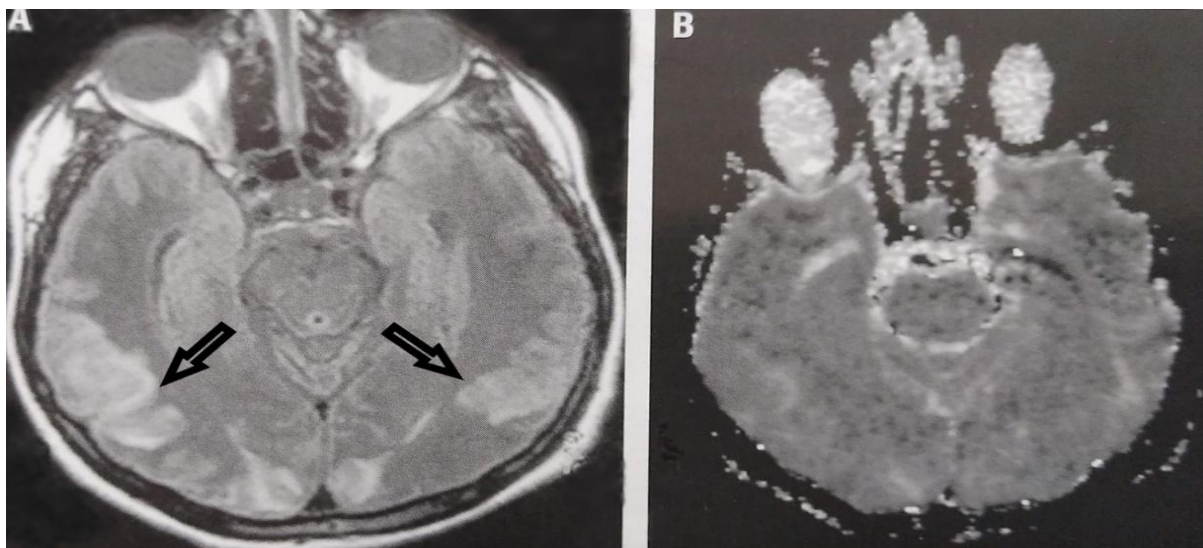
A. Fluid-attenuated inversion application recovery (FLAIR) sections. Symmetrical hyperintense vasogenic edema findings in bilateral occipitotemporal regions. B. Apparent diffusion coefficient (ADC) map showed high signal
